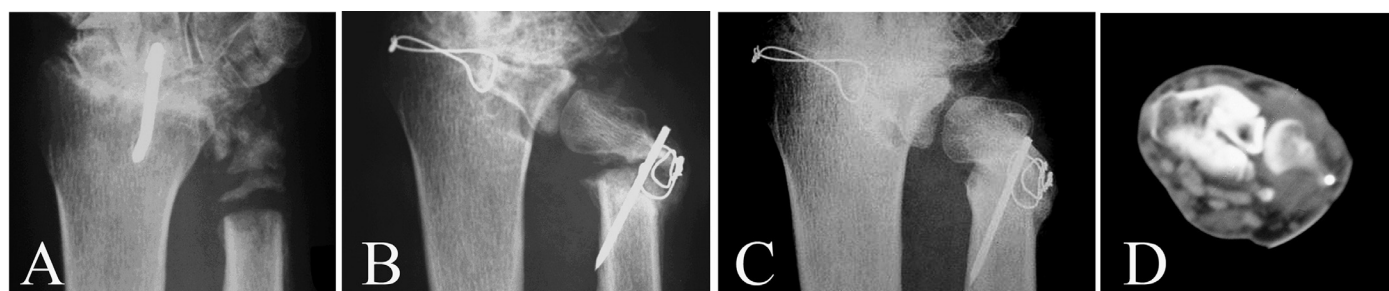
Case 3. 50-year old male. Operated in May 1994. (a) Preoperative X-ray. Caput ulna had been used as a bone graft for wrist arthrodesis one year earlier. (b) Early (1 month) postoperative X-ray showing a good alignment of the MTP-II graft as neo-DRU-joint. (c) X-ray at 1-year postoperatively. Joint transfer is well integrated to its place. (d) CT-scan at neo-DRU-joint level taken in semi pronated position 9 months postoperatively. Healthy articular contacts can be seen between metatarsal and proximal phalanx.
